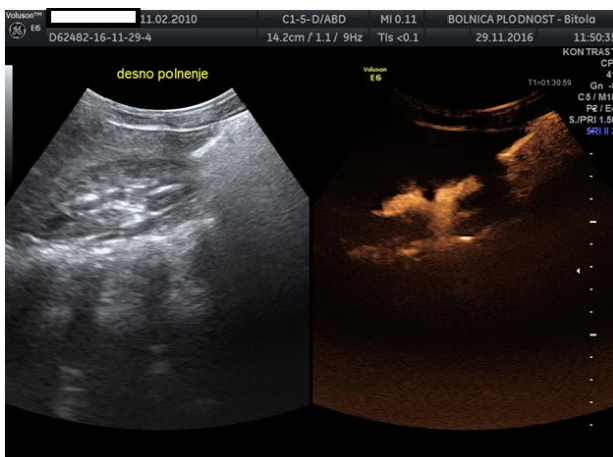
Ultrasound contrast agent in the collecting system of the right kidney using contrast specific software, B-mod "grayscale" (left) B-mod + contrast specific software (right)
